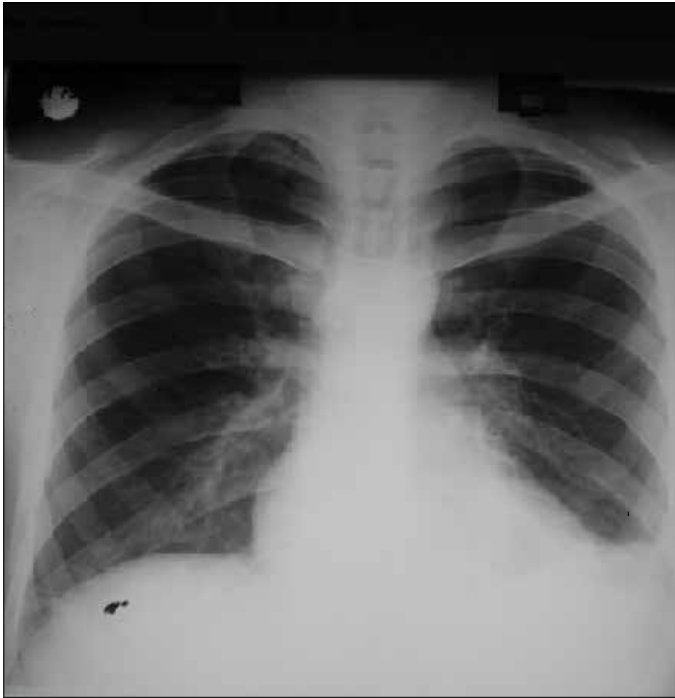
Postero-anterior chest x-ray
